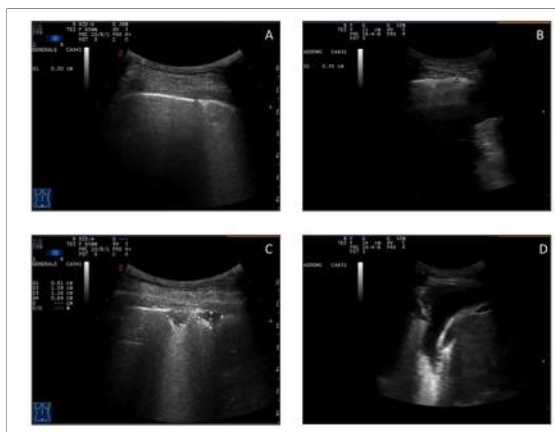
Ultrasound thoracic imaging. A). Normal pleural line. B). Pleural thickening. C). Subpleural lesions. D). Pleural effusion.
